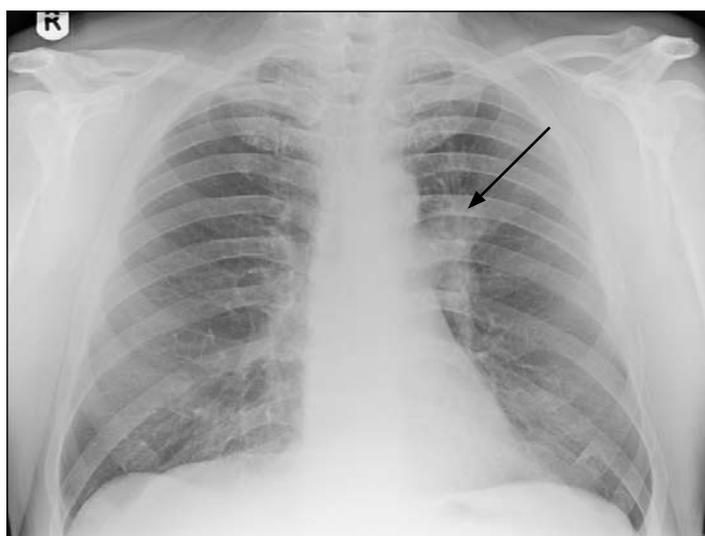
Chest Xray and CT scans showing a left upper lobe tumour
